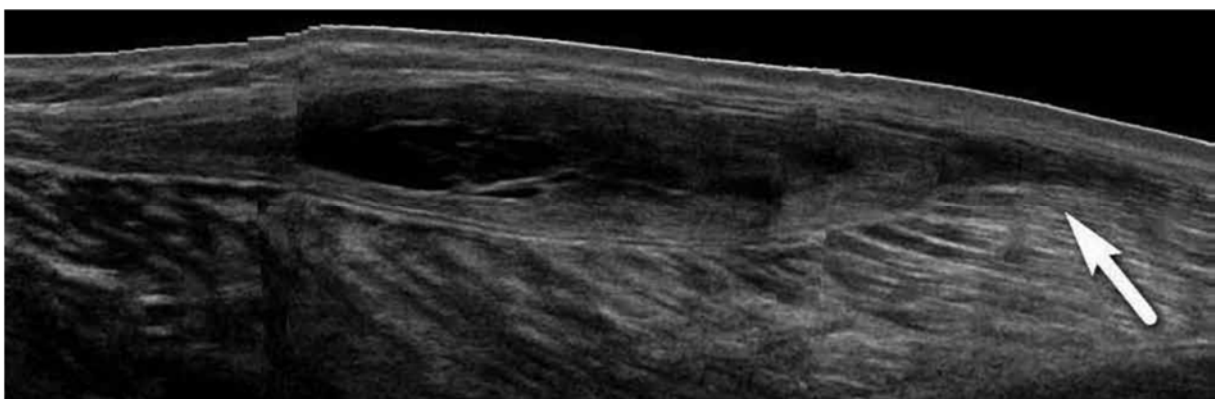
Complicated Baker's cyst: leakage is shown. A longitudinal sonogram shows a Baker's cyst with pointed appearance of distal end (arrow), indicative of recent leakage.(126)*
